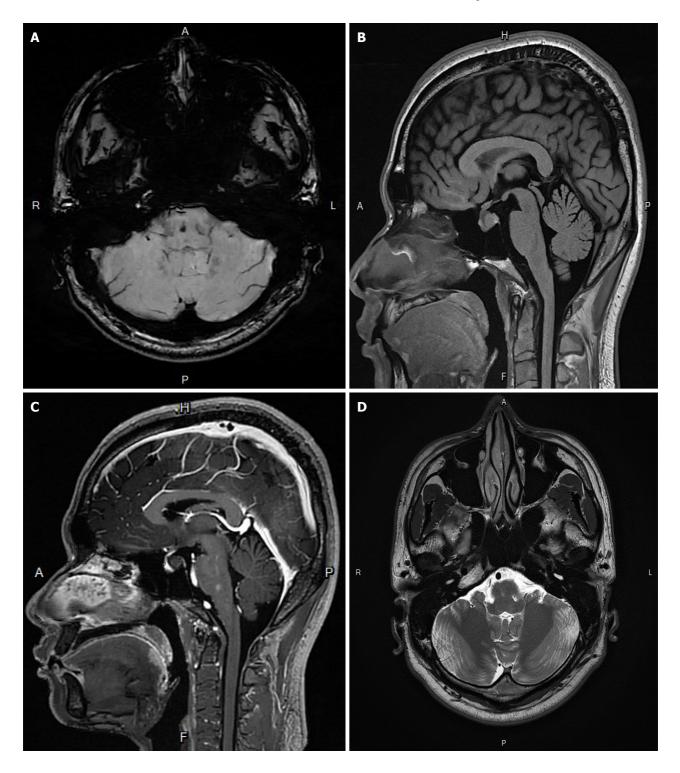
Head magnetic resonance imaging images. A: Magnetic resonance imaging of head; B: T1-weighted image (T1WI); C: T1WI after enhancement; D: T2-weighted image.
